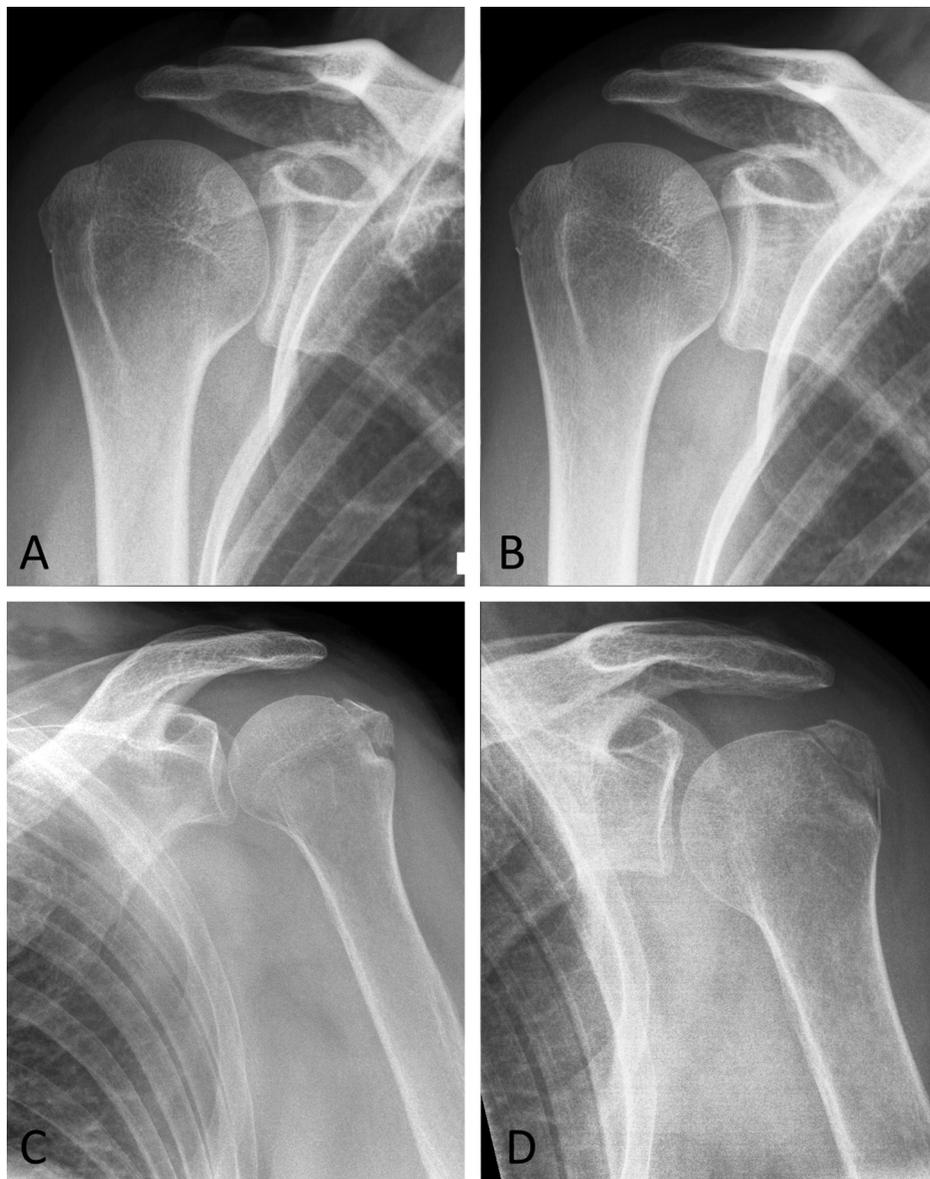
Radiographs of representative cases. Posttraumatic (A) and (B) follow-up radiographs of a non-displaced case (distance: 1 mm), compared to a patient presenting with secondary displacement (distance: 7 mm) between trauma (C) and follow-up at 10 days (D).
